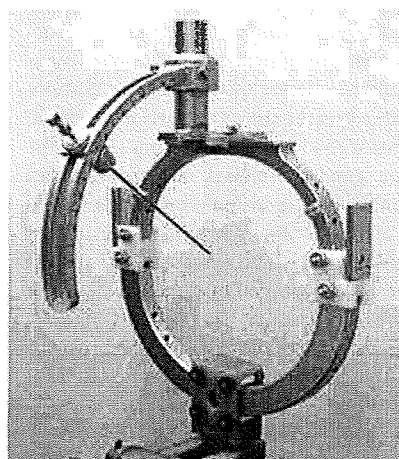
Radiofrequency receiver coil integrated with a modified Komai stereotactic frame for stereotactically guided surgical procedures under the control of intraoperative MRI.
